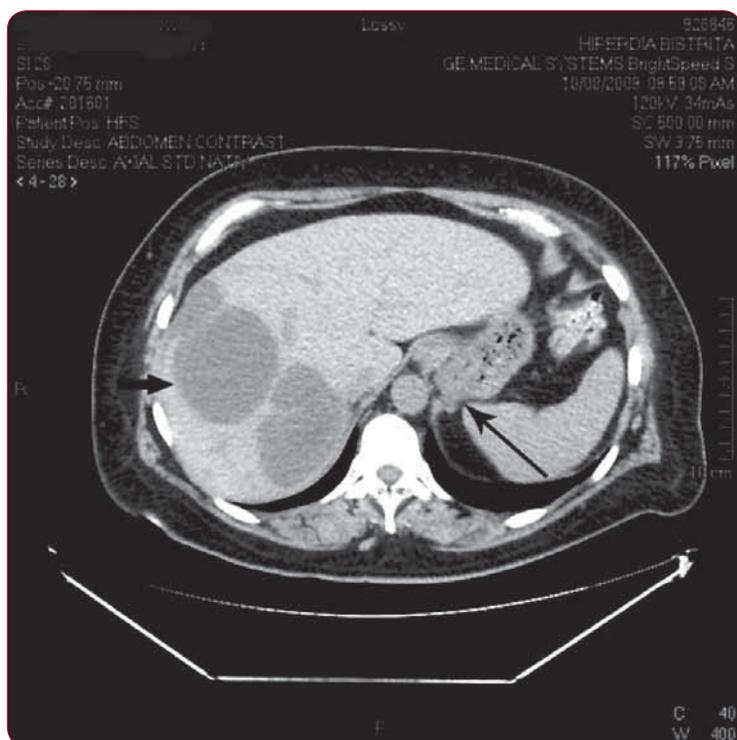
Computed tomography after treatment. Compared with previous CT, the wall of the hepatic tumour became thinner (small arrow) and the size of gastric tumour is reduced (big arrow)
